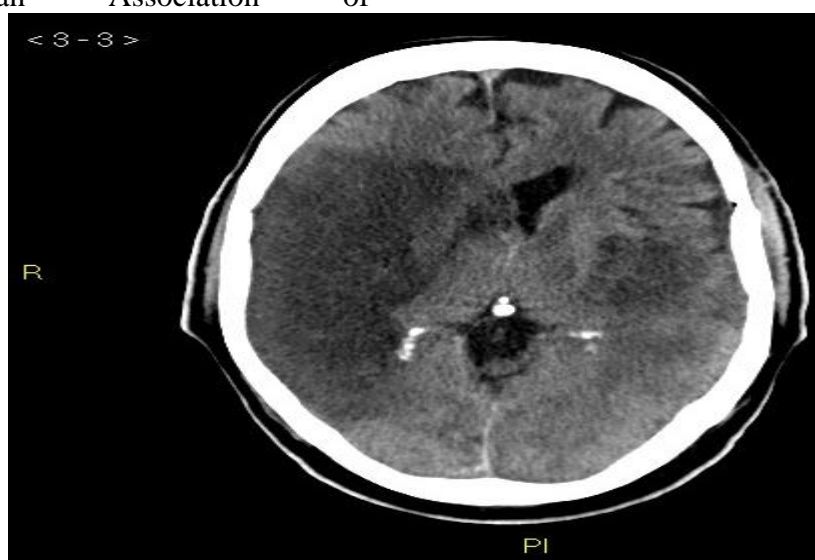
CT brain showing ischemic stroke
